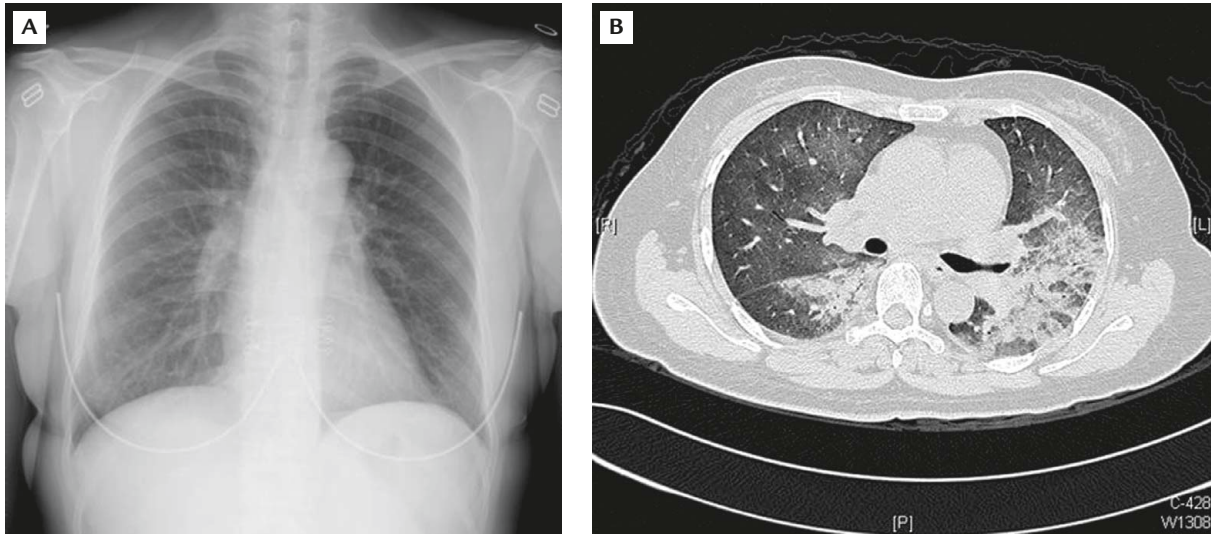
(A) Chest X-ray of Case 1 shows some ground glass appearance in the left lung and right lower lung fields. (B) High-resolution computed tomography shows patchy consolidation of bilateral perihilar areas.
